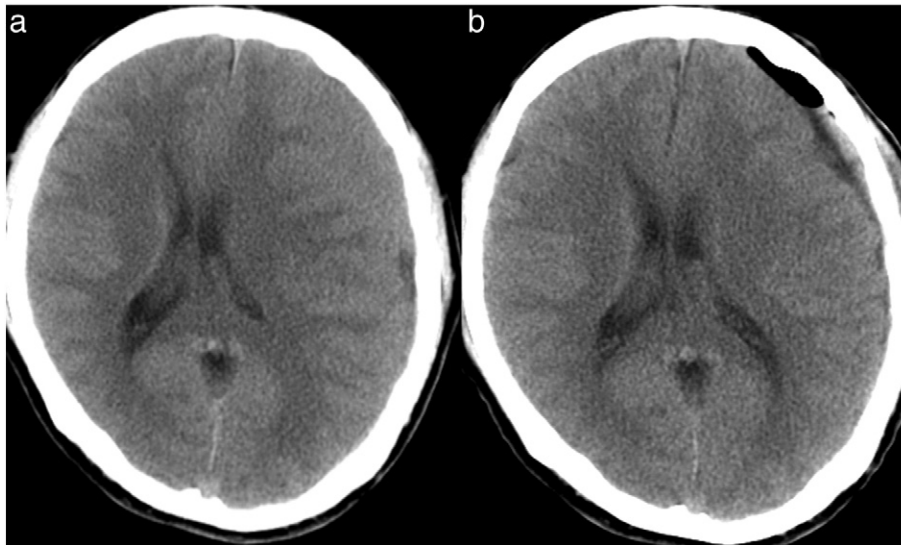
Pre-operative CT scan showing a supratentorial CSDH and compression of the left hemisphere. a. CT scan obtained on the 1st postoperative day. Most of the CSDH had disappeared. Note recovery of the midline shift (b).
